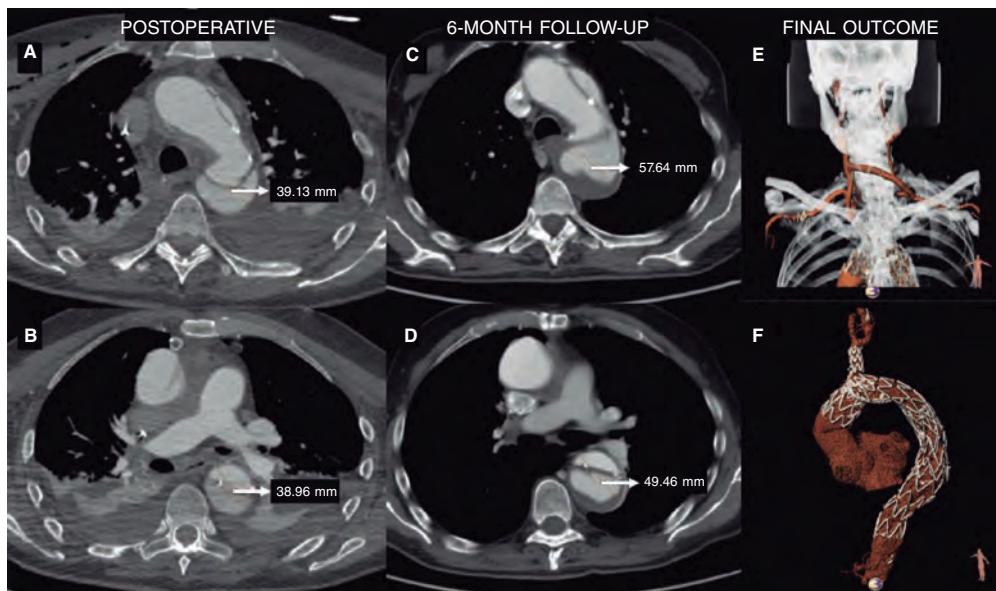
A, B, C, D: aortic enlargement after open ascending aorta replacement as seen on the coronary computed tomography angiogram performed at the 6-month follow-up. E: extra-anatomic reconstruction with right common carotid artery to left subclavian artery bypass (both end-to-side), proximal ligation, and end-to-side reimplantation of the right common carotid artery on the graft. F: ascending aorta open replacement, NEXUS Stent Graft System implantation into aortic arch and descending thoracic aorta with false lumen thrombosis.
